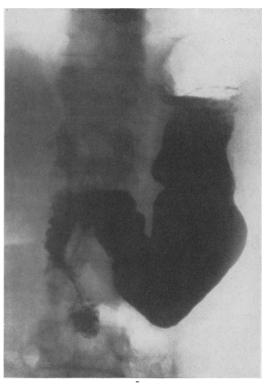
Roentgenogram taken four weeks postoperationem in Case 2: Normal.
